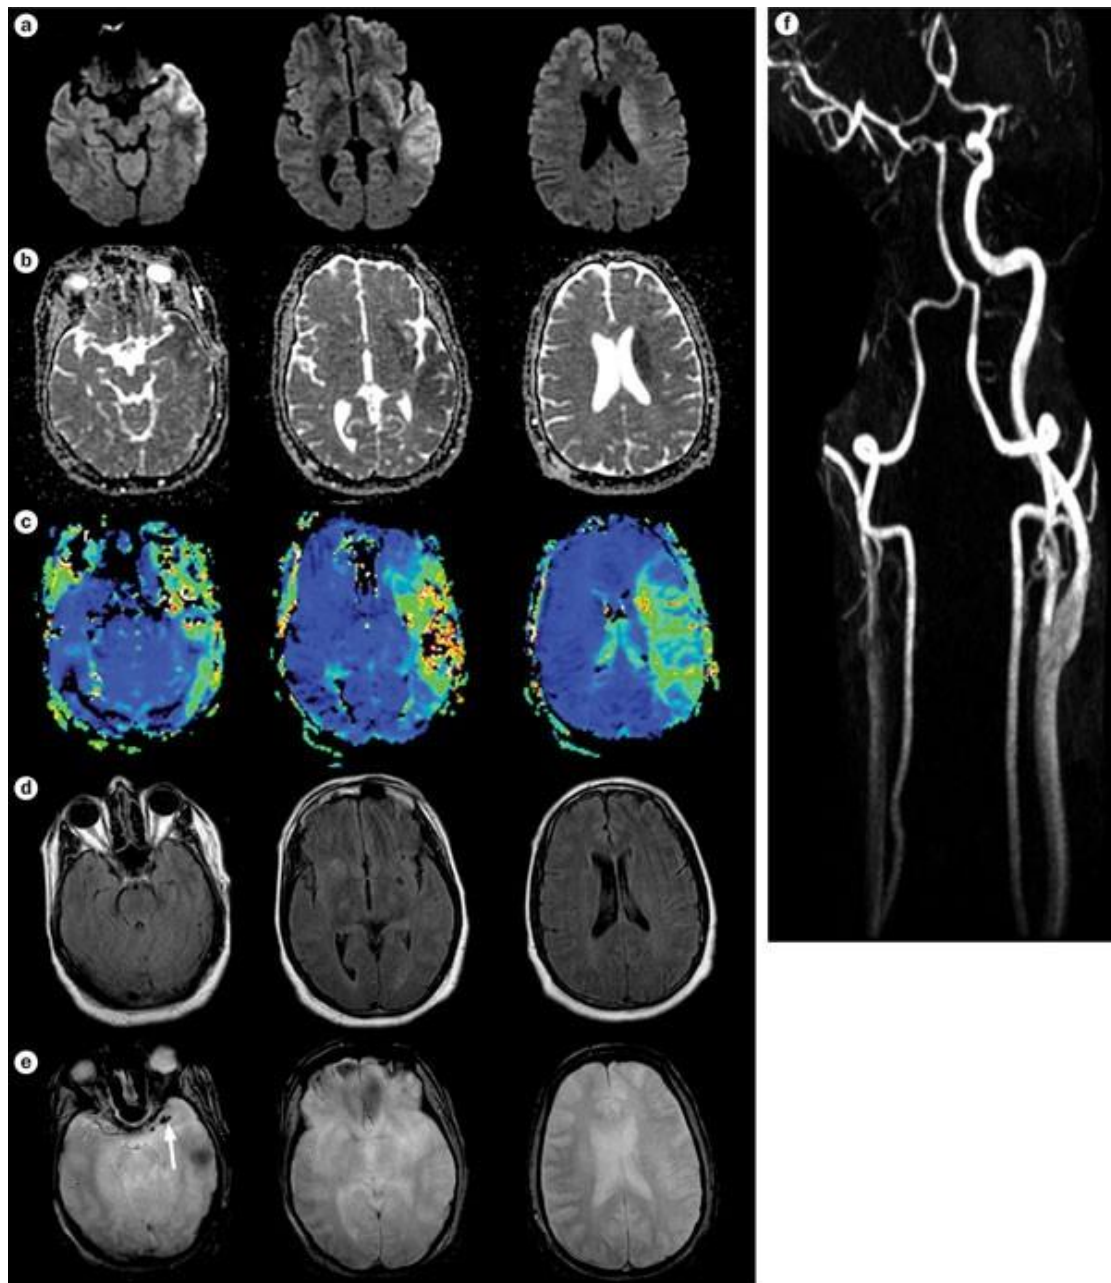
The patient arrived at the emergency room 45 min after symptom onset. MRI was started 20 min later, and the patient was treated with intravenous tissue plasminogen activator 55 min after arrival. a | DWI sequence showed an area of hyperintensity in the right temporal, insular and frontal lobes. b | Apparent diffusion coefficient map showed a matching area of hypointensity, confirming that the DWI lesion was due to acute ischemia. c | Mean transit time maps showed an area of hypoperfused tissue larger than the DWI abnormality; the difference represented the penumbra. d | Fluid-attenuated inversion recovery showed no matching hyperintensity, indicating that the DWI lesion was <6 h old. e | The gradient-recalled echo sequence showed no evidence of acute or chronic hemorrhage, but a clot was seen in the right MCA (arrow). f | Contrast-enhanced MRA of the neck and brain revealed a chronic asymptomatic right carotid occlusion, although the patient had good collateral flow through the anterior communicating artery, and his right
